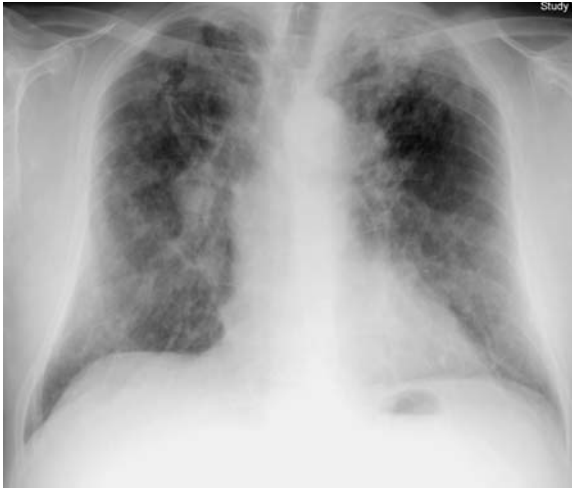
Chest radiograph in a patient with advanced chronic beryllium disease shows abnormality predominating in the upper lobes, consisting of coarse well-defined nodules, which appear to coalesce in areas. Some of the nodules appear calcified. There is moderate upper lobe volume loss with superior hilar retraction and some anatomic distortion. Hilar enlargement is likely due to a combination of adenopathy and pulmonary arterial enlargement due to pulmonary hypertension
